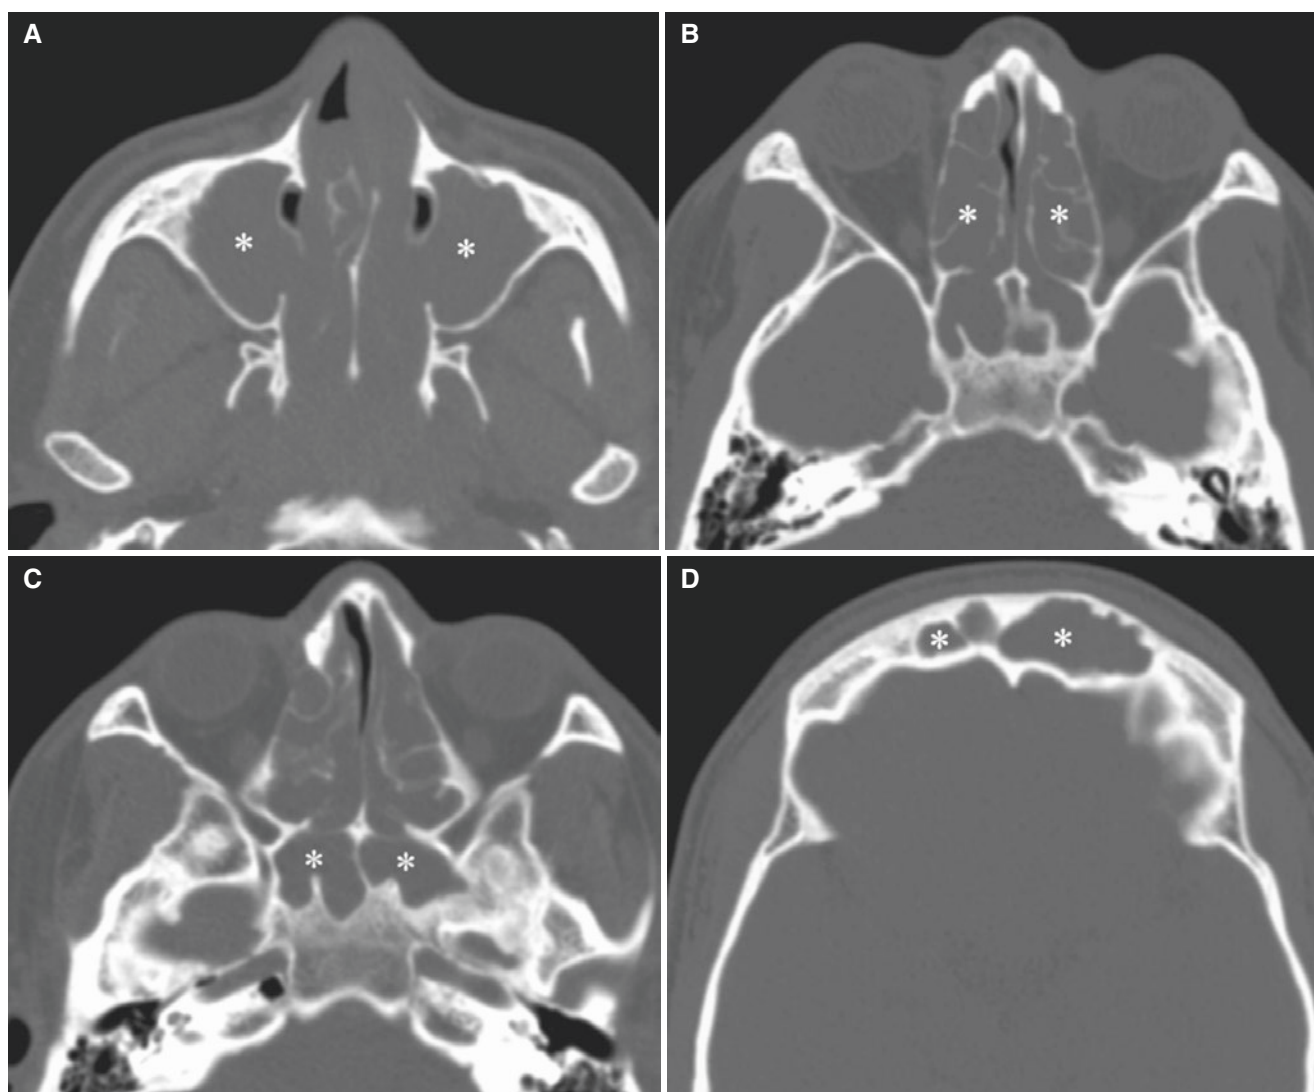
Pansinusitis; 19-year-old male with history of sinusitis and cough, now with headache and eye and cheek pain. (A) Axial CT image shows complete opacification of the maxillary sinuses (*asterisks*). (B) Axial CT image shows complete opacification of ethmoid sinuses
